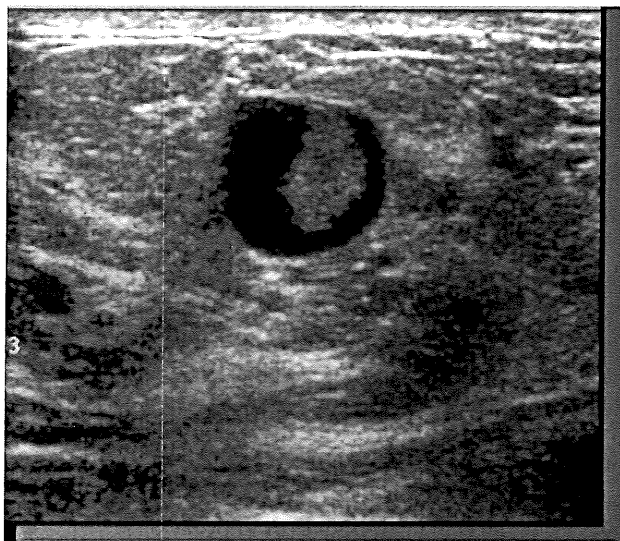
Solitary breast papilloma by ultrasound. Ultrasound reveals an isoechoic, circumscribed intraductal mass
